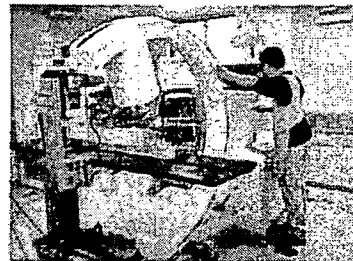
The robot can be installed between a patient and C-Arm X-Ray Equipment
